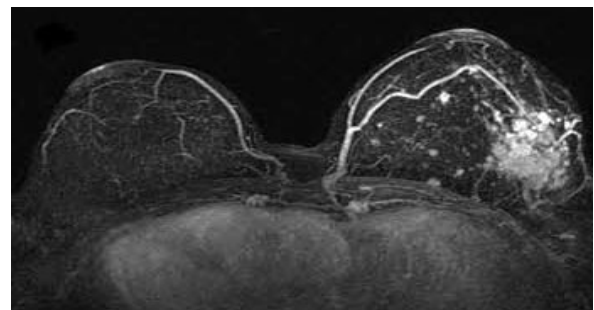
MRI Imaging of cancer in the right breast
